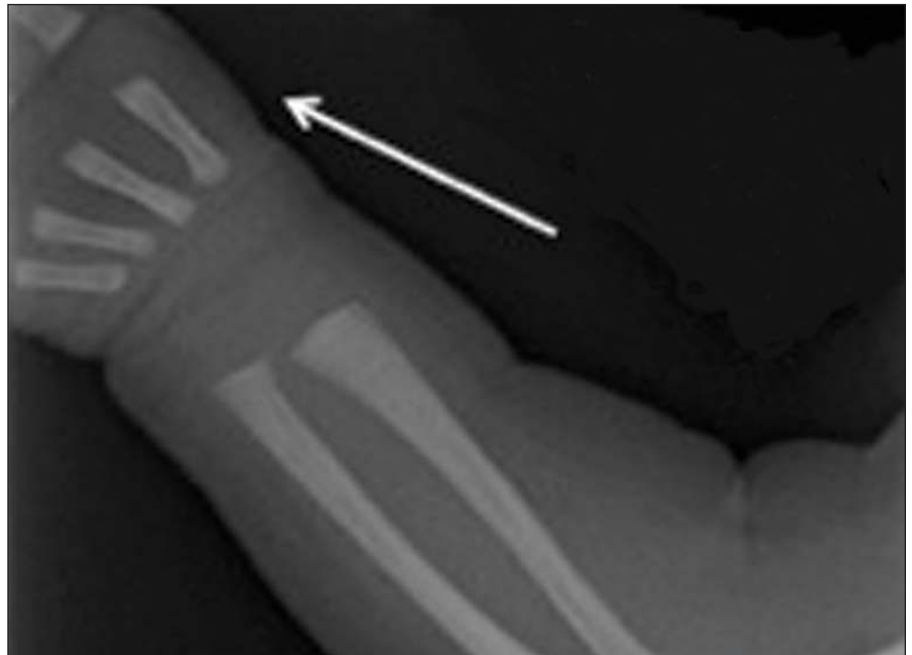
Radiograph of right upper extremity revealed an absent right thumb.
